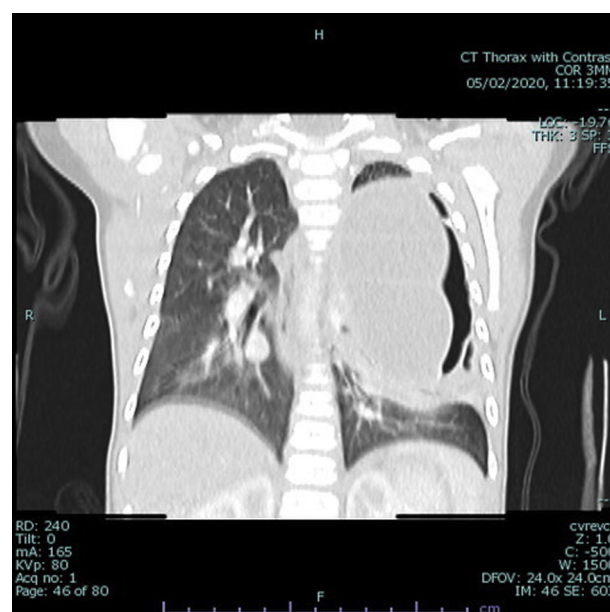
Computed tomography scan of the chest showing a large multiloculated fluid-filled mass within the left hemithorax causing mediastinal deviation to the right.
